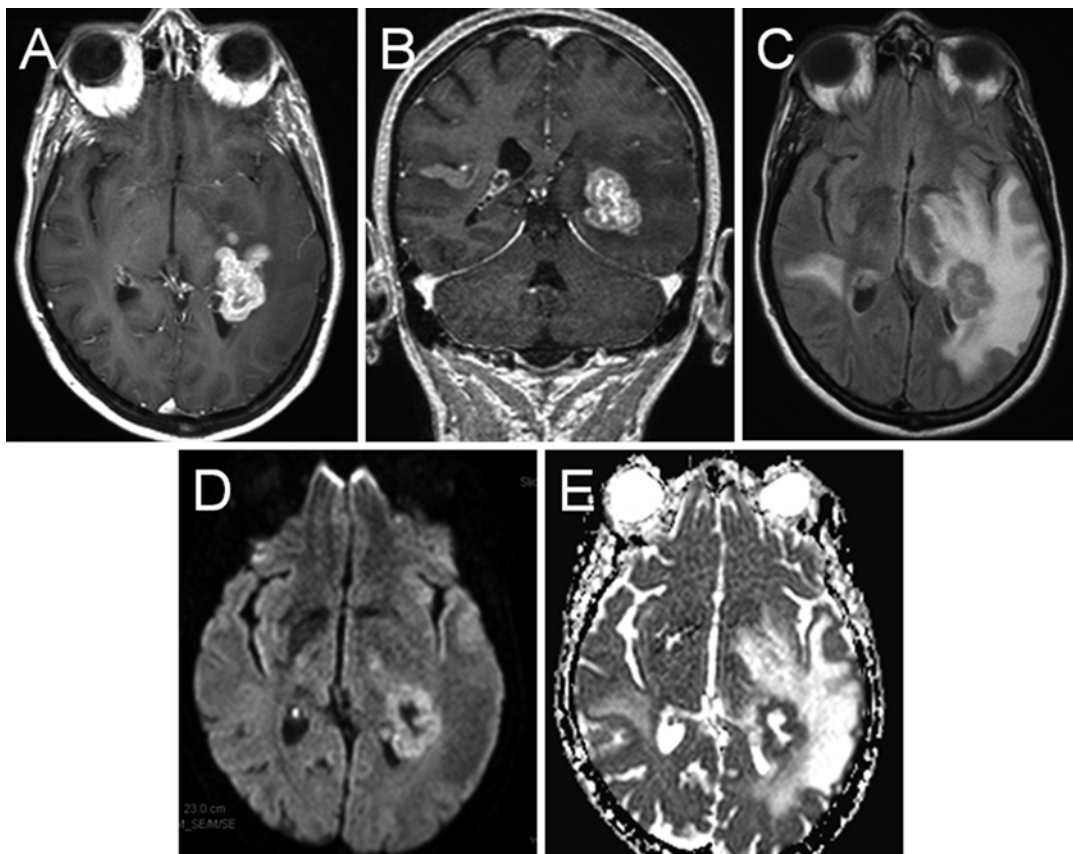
MRI characteristics of diffuse large B-cell lymphoma. T1-weighted axial (a) and coronal (b) post-contrast imaging reveals an avidly contrast-enhancing mass lesion in the deep white matter with extension into
